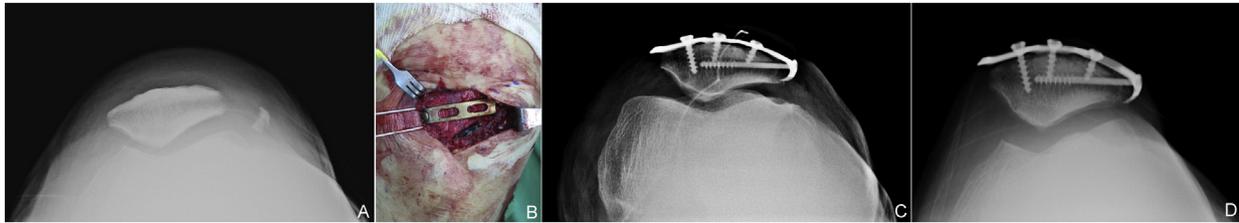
Forty-eight-year-old male patient. A. Lateral marginal fracture in the skyline view. B. Hook plating. C. Postoperative radiograph. D. Eight-week postoperative radiograph.
